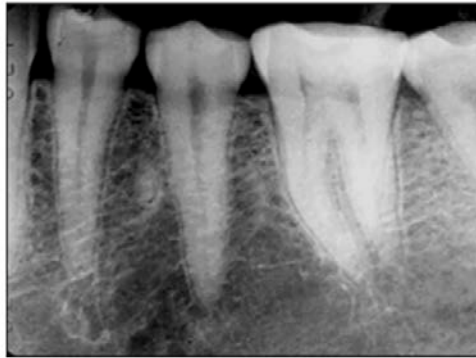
Periapical radiograph of posterior teeth with attrition.
